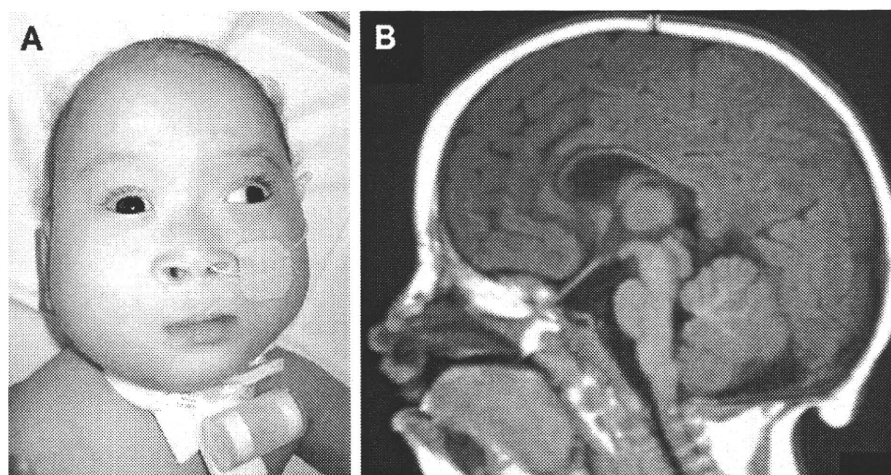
Clinical information of the patient. A: A picture at the age of 1 years and 8 months. The prominent forehead, sparse hair and eyebrows, hypertelorism, a wide and depressed nasal bridge, a short nose with wide and anteverted nares, up-slanting palpebral fissures, epicanthic folds, full cheeks, a long philtrum, micrognathia, and a short neck can be seen. B: A sagittal image of the brain MRI indicates hypoplasia of the corpus callosum.
